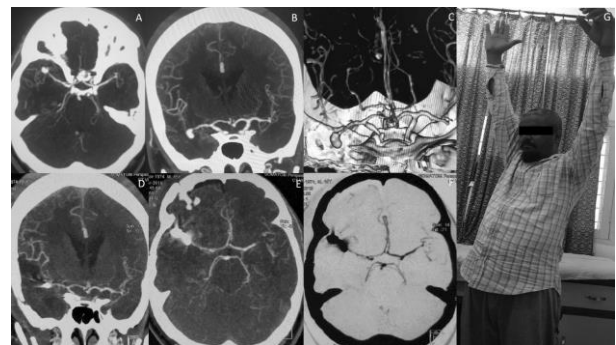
Computed tomography angiography of patient with multiple intracranial aneurysm (right middle cerebral artery bifurcation and right ophthalmic aneurysm), axial view (A) showing laterally projecting aneurysm right middle cerebral artery bifurcation aneurysm. Coronal view (B) and Three dimensional CT (C) showing the inferiorly projecting right MCA bifurcation and medially projecting right ophthalmic aneurysm. Post op Computed tomography angiography, coronal view (D), axial (F and G) showing complete occlusion of both aneurysms. (G) Patient is fine with no deficit.
